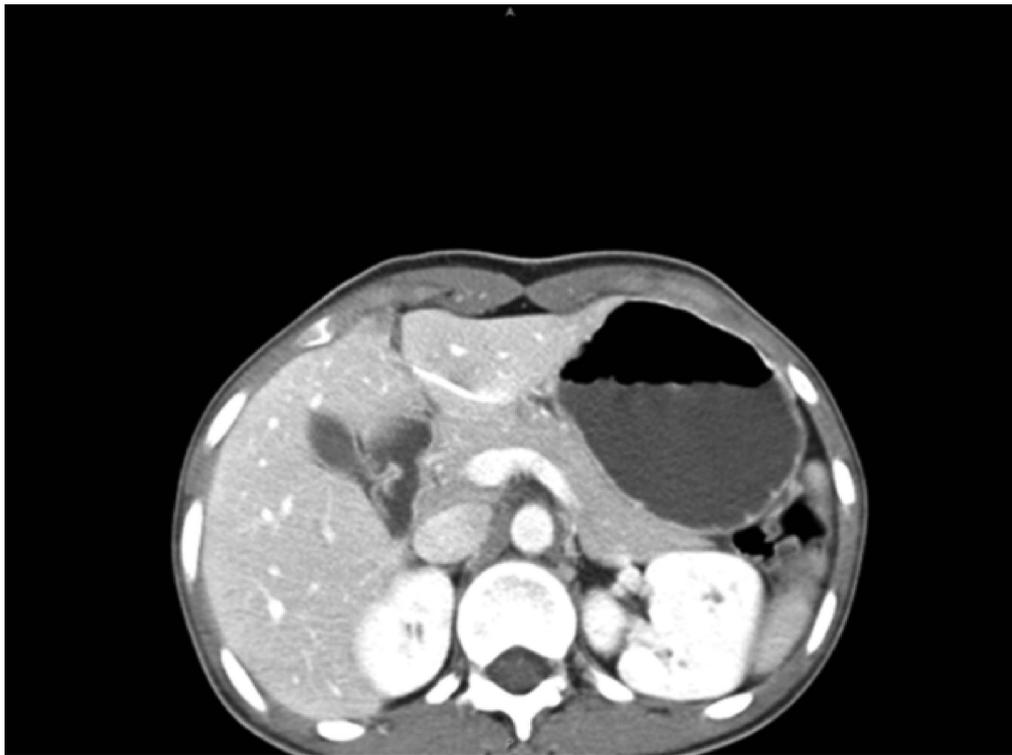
CT abdomen with contrast showing the radio-opaque linear foreign body in the left lobe of the liver.
